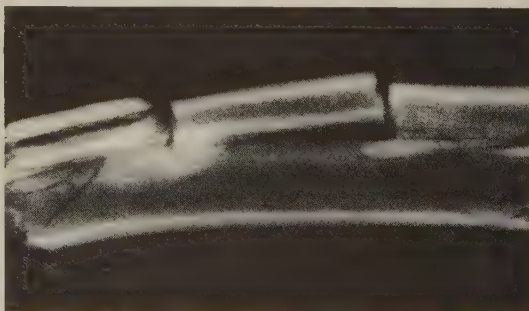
Roentgenogram of undecalcified implanted bone 4 weeks postoperatively.
